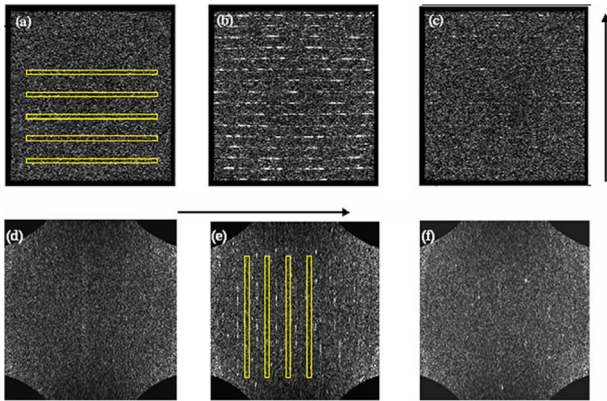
Comparison of MR image noise at 3 T (upper row) and 0.5 T (lower row) under various conditions of US setup with MR RF transmitter powered off, [(a), (d)] baseline image without US, [(b), (e)] during US capturing with US system shielded and probe window unshielded, [(c), (f)] during US capturing with shielded US system and shielded probe window. The arrows indicate the direction of frequency encoding. Rectangles indicate the ROI drawn for noise measurements.
